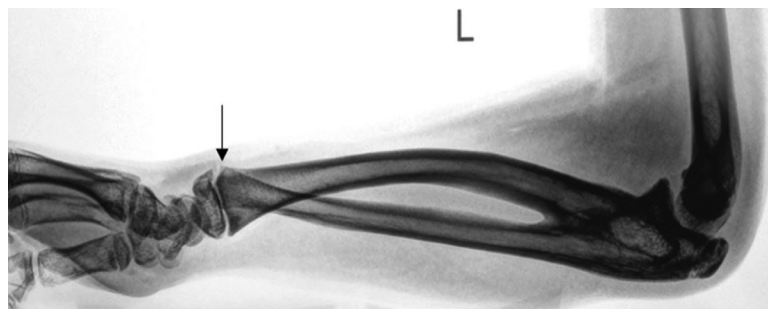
Radiograph of the forearm of a patient with CRUS in a strictly lateral projection with the arrow indicating the dorsal subluxation of the ulnar head
